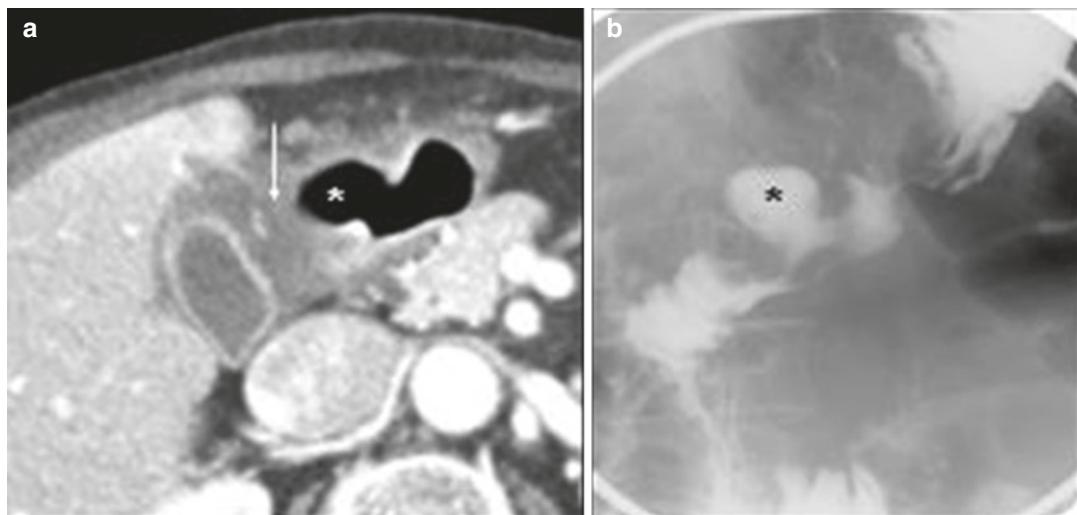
Penetrating duodenal bulb ulcer causing secondary cholecystitis in an 80-year-old woman presenting with right upper quadrant pain. Axial abdominal CT image with intravenous contrast (a) shows a large duodenal bulb
